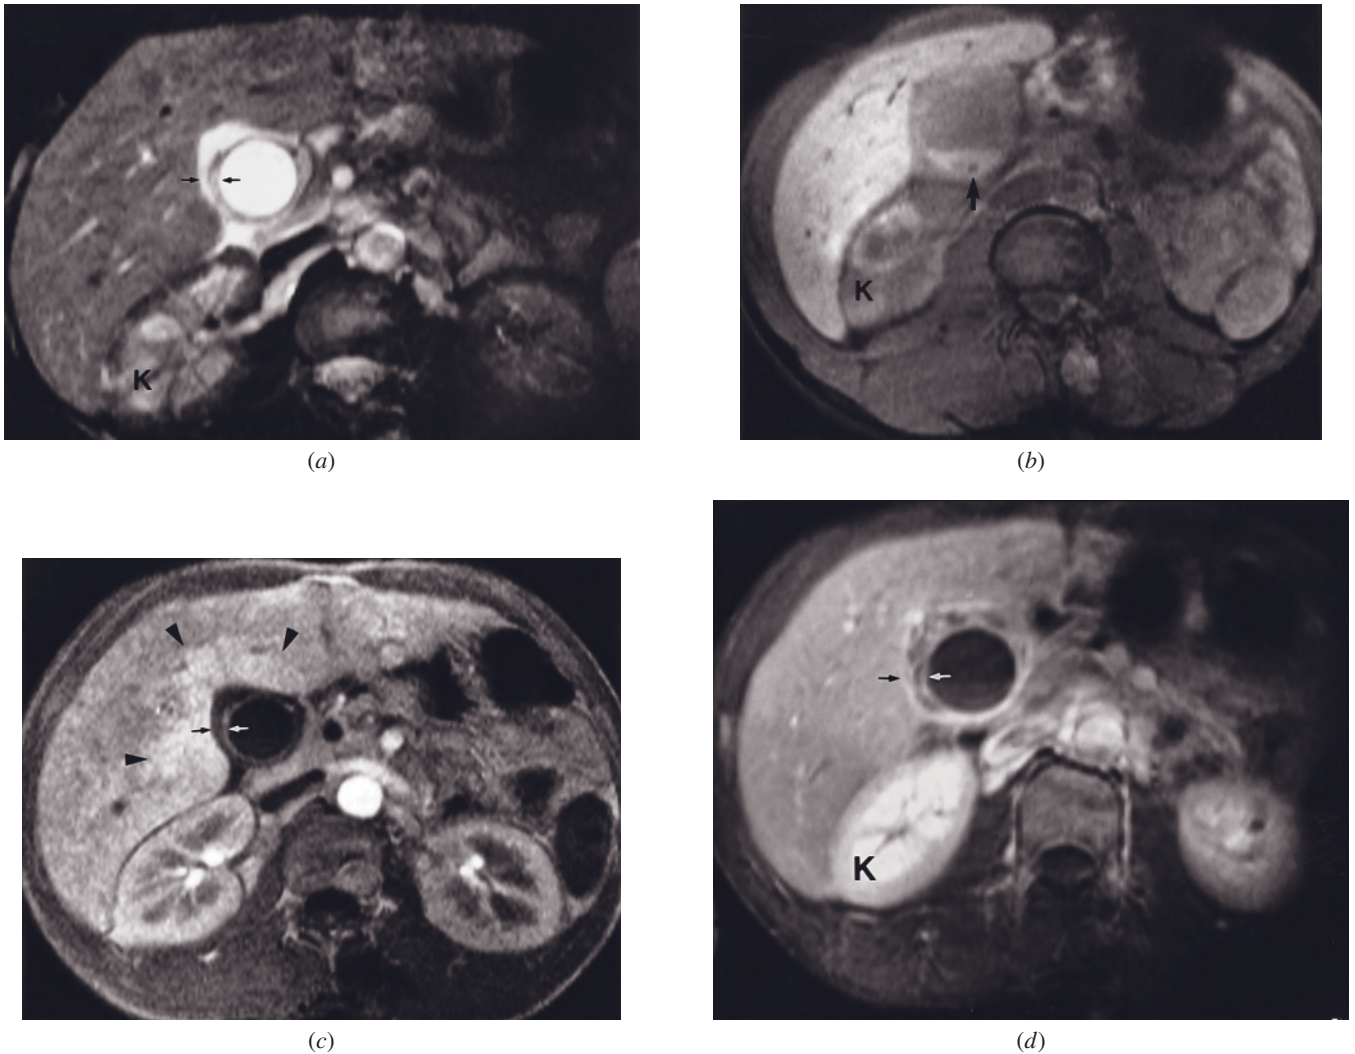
Acute on chronic cholecystitis. T2-weighted fat-suppressed echo-train spin-echo (*a*), T1-weighted fat-suppressed spin-echo (*b*), immediate postgadolinium GE (*c*), and 2-min postgadolinium fat-suppressed spin-echo (*d*) images. The gallbladder wall is thickened (arrows, *a*, *c*, *d*) with increased mural signal intensity on the T2-weighted image (*a*). On the T1-weighted image (*b*), layering of high-signal concentrated bile in the dependent portion and a small, hypointense, gallbladder stone (arrow, *b*) are shown.
